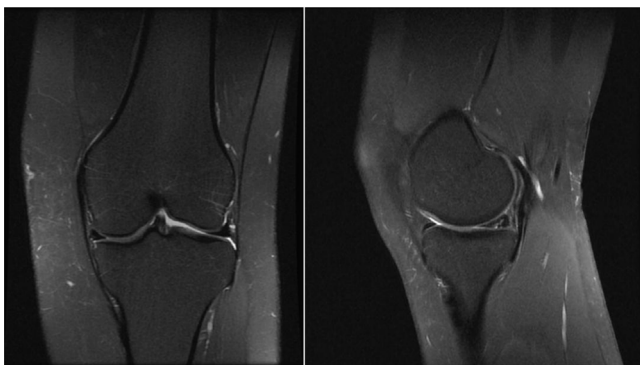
Type II images on MRI; patient treated for lesions in the middle and posterior segments of the medial meniscus.
